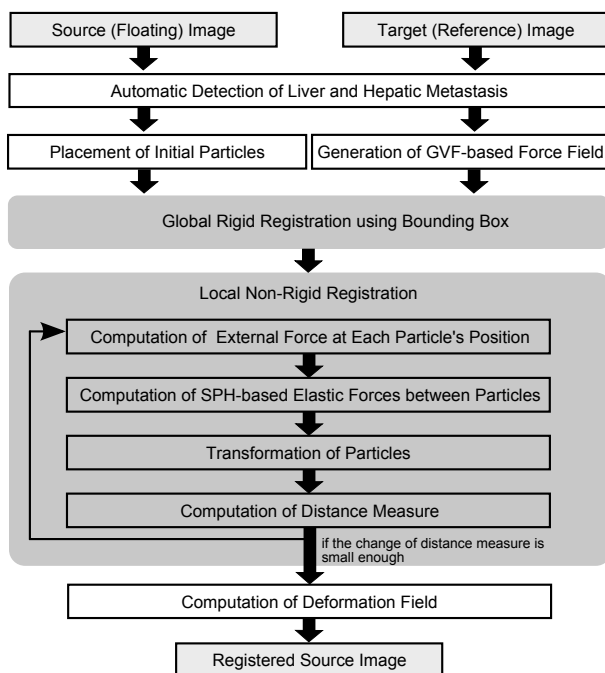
Process of particle-based volume preserving follow-up liver CT registration
